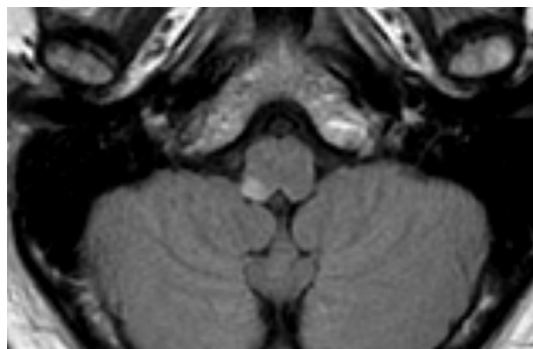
Lateral medullary syndrome. FLAIR image demonstrates acute infarct involving the right dorsal-lateral medulla.
